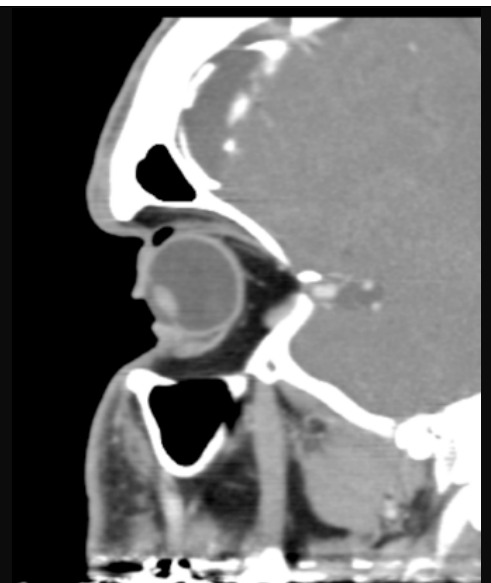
CT scan, sagittal view, demonstrating the upward bowing of the orbital roof and air entrapment under the upper eyelid
